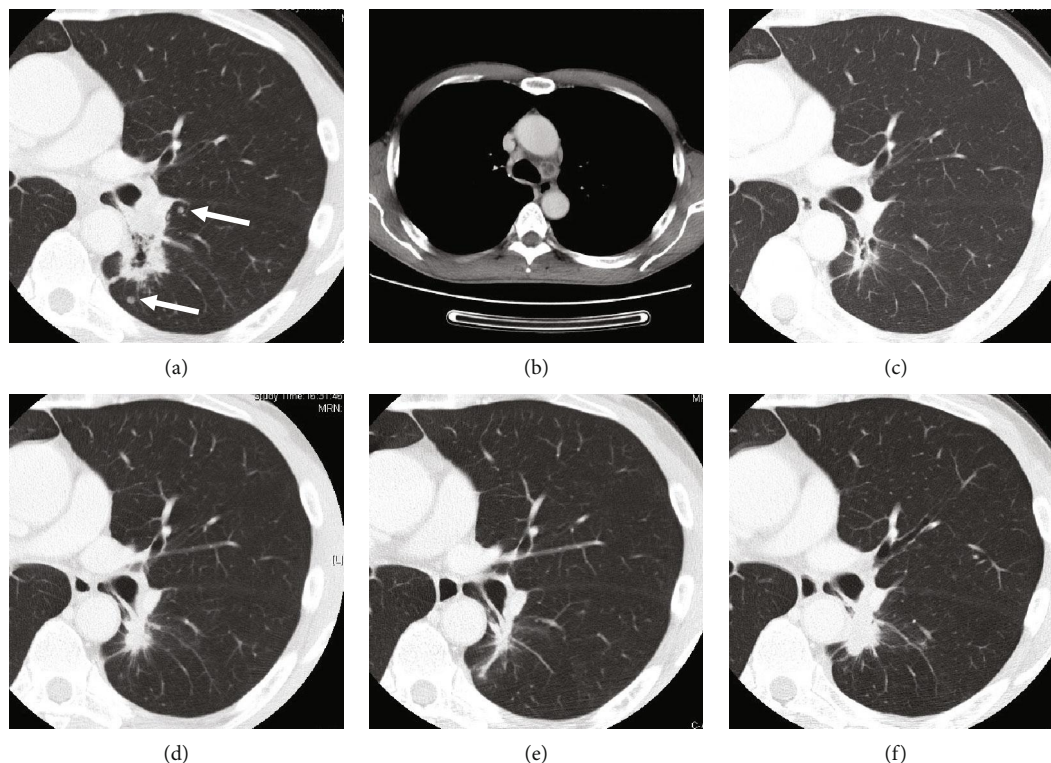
Chest CT scan. Chest CT scan performed on admission (a, b) four months after afatinib treatment (c) before the initiation of gefitinib (d) two months after gefitinib treatment (e) and six months after gefitinib treatment (f). Arrows indicate separate tumor nodules in the same lobe as the primary tumor.
